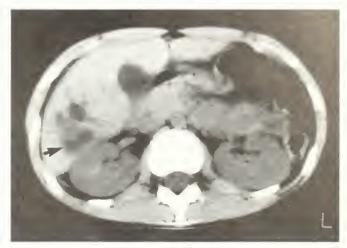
CT scan demonstrating liver contusion in a 13-year-old girl injured in a motor vehicle accident.
